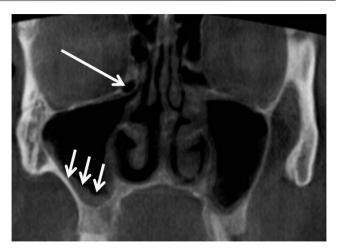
Coronal cone beam CT shows, Haller cell (long arrow), mucosal thickening of right maxillary sinus (short arrow).
